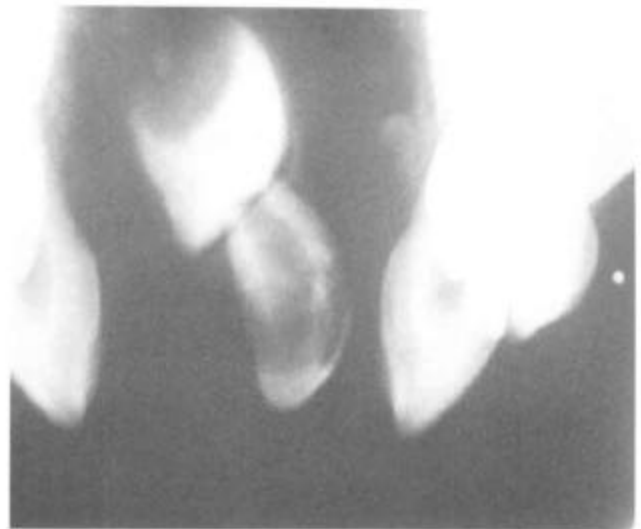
Anteroposterior cephalogram (*left*) and occlusal x-ray of single central incisor (*right*) in Case 2 at 3 years, 7 months of age.
